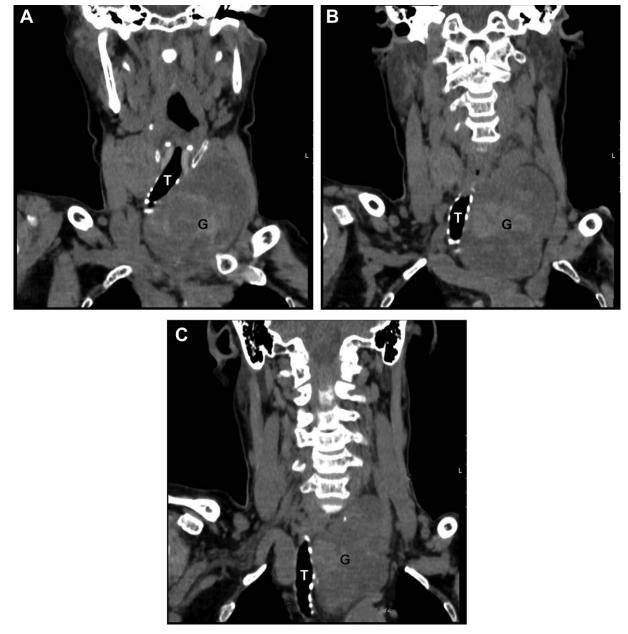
A–C. The displacement of the trachea (T) by the goiter (G) can be clearly observed at CT scans.
